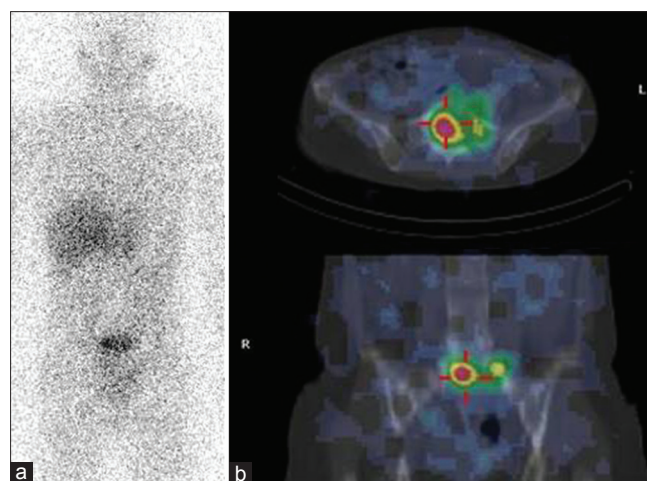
(a) The ¹³¹I-MIBG planar images at 48 h reveal abnormal tracer activity in the pelvic region; (b) SPECT/CT images of same patient show the abnormal tracer activity localized to sacrum suggestive of metastasis
